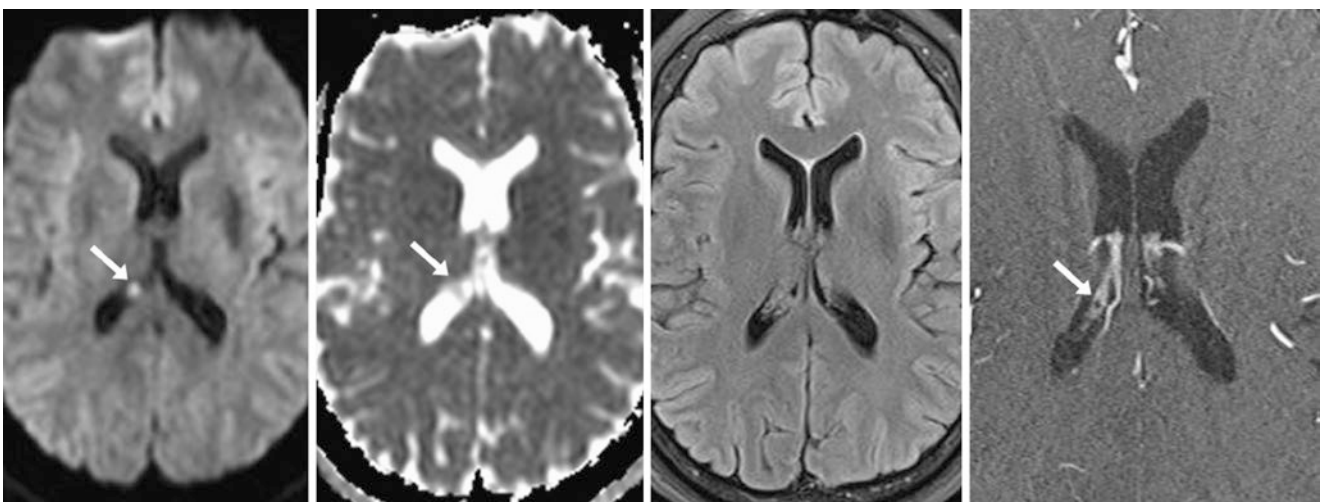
A 50 year old with a tiny, unilateral right CPXG (arrows) on a 3 T MRI, measuring 2 mm as noted on axial DWI (left) and the corresponding ADC map (left middle). This focus was not seen on
